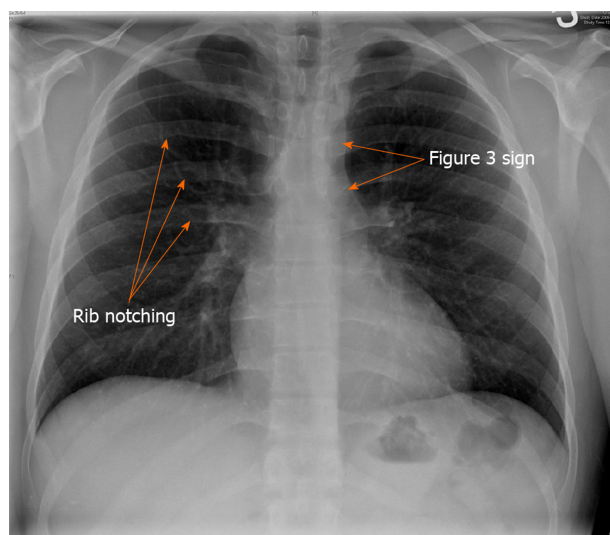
Chest X-Ray demonstrating rib notching and Figure 3 sign.
